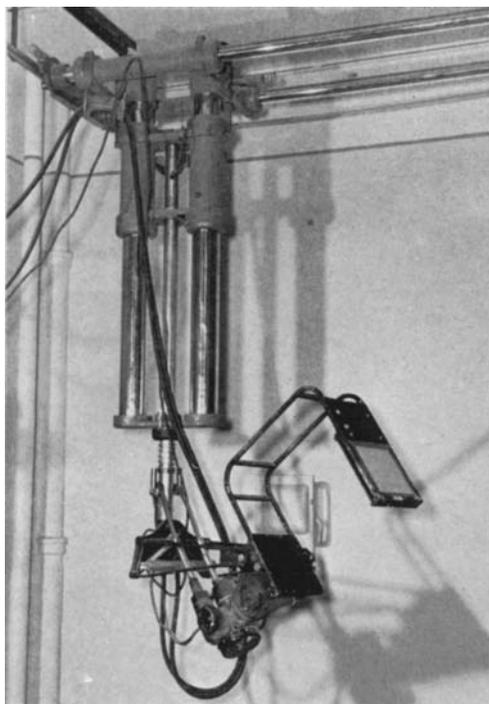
This home-made "multiplane" fluoroscope at Temple University Hospital was designed particularly for visualizing fracture fragments before and after manipulation, but it has many other possibilities. Note the "traveling crane" type of ceiling mounting to permit free movement about the room. X-ray beam is readily angulated in any direction at the will of the operator. The C-shaped arm which connects tube housing and screen insures correct alignment of x-ray beam with lead glass protection. With this device we have been able to control the insertion of the Smith-Petersen nail in cases of intracapsular fracture of femoral neck.
